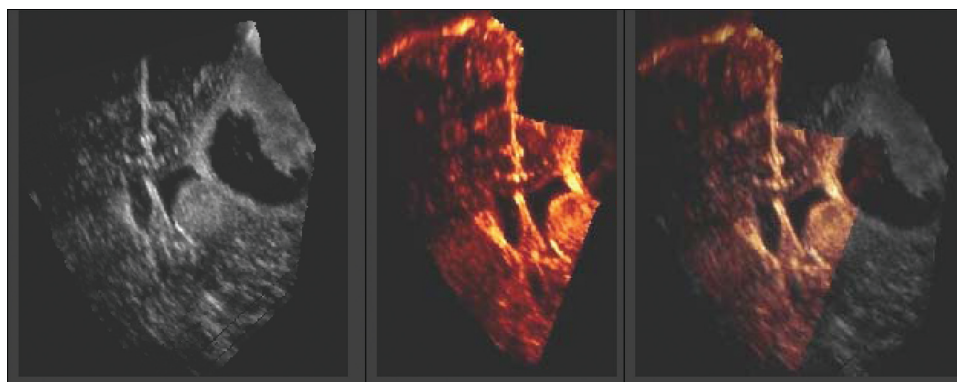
Reslices of two preresection ultrasounds sweeps for patient #6. Left: sweep #6a. Center: sweep #6b. Right: sweep #6a overlaid on sweep #6b.
